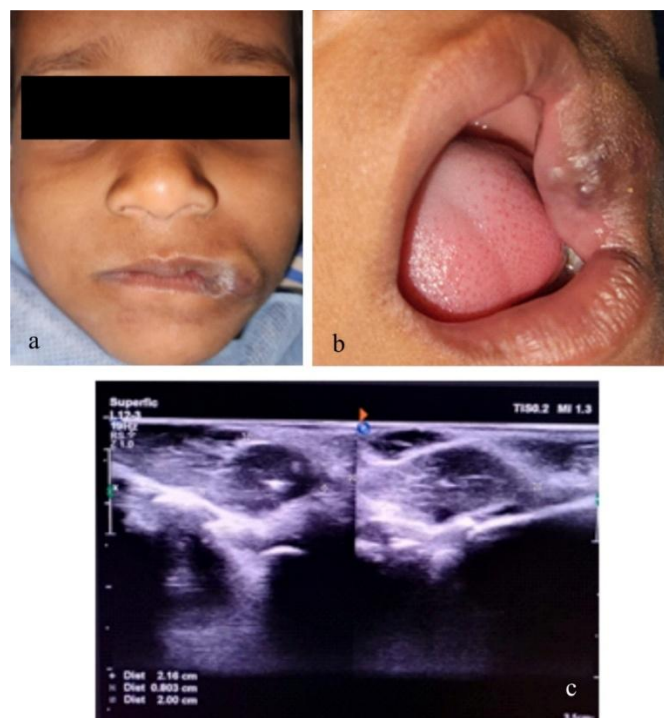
(a) and (b) Preoperative clinical photographs showing well defined reddish-brown swelling involving left angle of mouth, lips and buccal mucosa, (c) Color Doppler Ultrasonography presenting predominantly hyperechoic soft tissue lesion and confirming the vascular origin.
